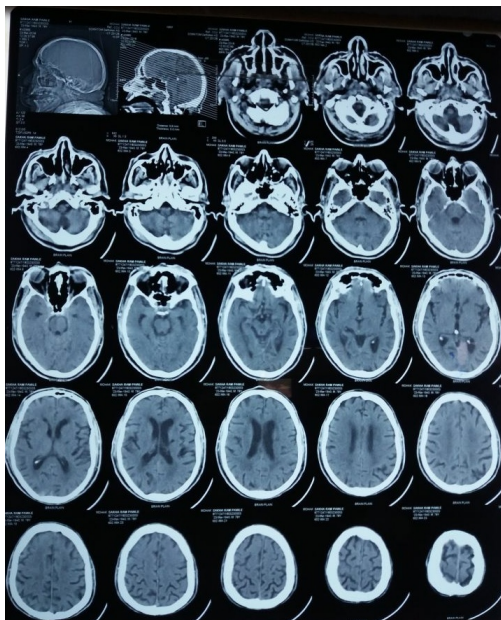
Baseline CT scan done immediately after stroke.
